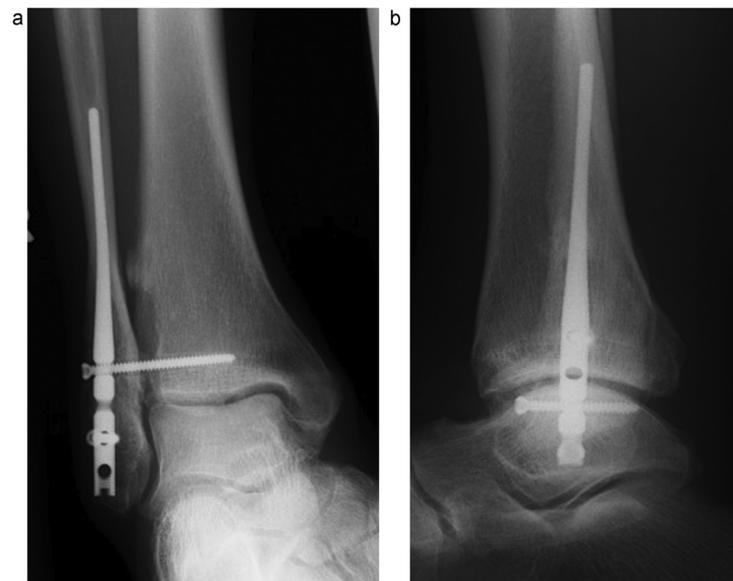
Anteroposterior (a) and lateral (b) radiographs of the same patient, two years following surgery, demonstrating healed lateral and medial malleolar fractures with no significant evidence of post-traumatic osteoarthritis.
